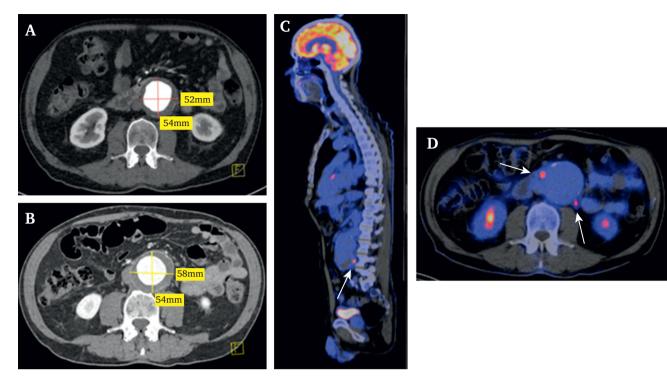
(A) Computed tomography (CT) angiogram of the abdomen (axial view) showing the abdominal aortic aneurysm with a maximum diameter of 54 mm. (B) CT angiogram of the abdomen (axial view) demonstrating a 58 mm diameter abdominal aortic aneurysm following a five month interval. (C) Fluorodeoxyglucose (FDG) positron emission tomography (PET) CT showing abnormal FDG uptake within the aneurysmal wall. Note: Moderately prominent radiotracer uptake in the left ventricular myocardium probably represents physiological tracer uptake related to the dietary preparation for the study and is not thought to represent endocarditis. (D) Axial view of the FDG PET CT.
